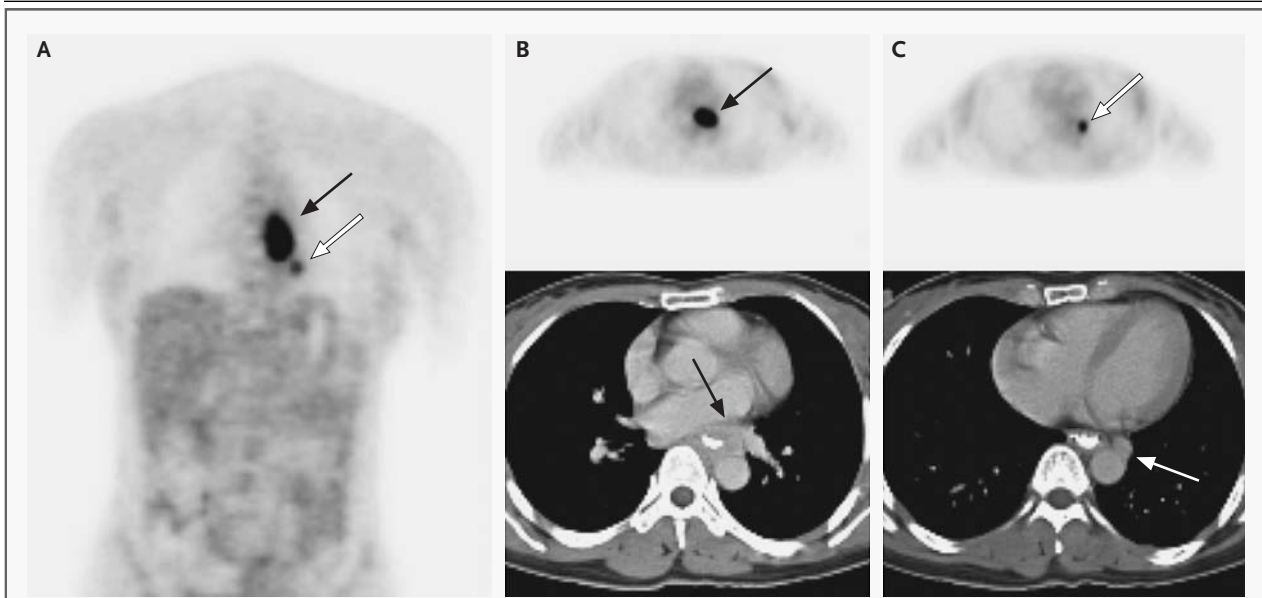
Cancer of the Distal Esophagus (Panels A and B) with Metastasis to a Paraesophageal Lymph Node (Panels A and C). Panel A shows a coronal section of a positron-emission tomographic (PET) study with fludeoxyglucose F 18. A cancer of the distal esophagus is present (black arrow) with metastasis to a paraesophageal lymph node (white arrow). Panels B and C show corresponding axial sections of the PET scan (top two images) and a CT scan (bottom two images); the cancer in the distal esophagus is indicated by the black arrows in Panel B, and the metastatic paraesophageal lymph node by the white arrows in Panel C. Courtesy of Annick D. Van den Abbeele, M.D.
